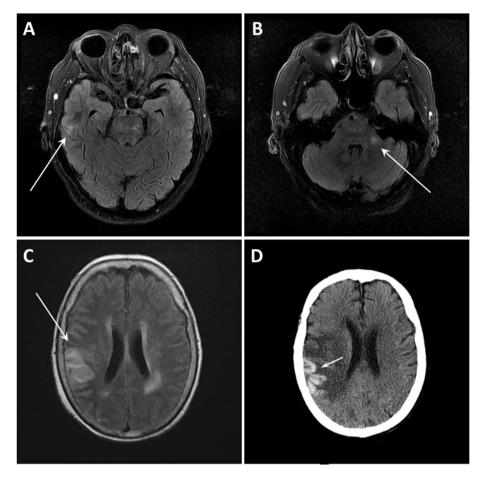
Brain imaging in a case of HSV encephalitis. (A) and (B) demonstrate T2 weighted brain MRI 1 day after presentation with arrows showing signal abnormalities in right temporal (A) and left middle cerebellar peduncle (B) regions. (C) shows T2 weighted MRI signal abnormality in the right parietal region (arrow) 11 days after presentation. (D) CT head shows laminar necrosis (arrow) in the right parietal lesion 37 days after presentation.
